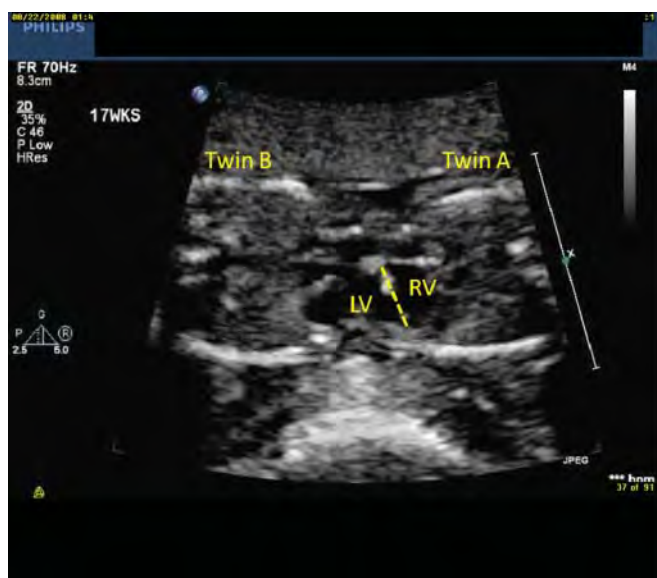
Fetal echocardiography of thoracopagus twins shown in Figure 48.3, at 17 weeks' gestation. The yellow dashed line demarcates the site of connection of the two hearts between the right ventricle (RV) of twin A and the left ventricle (LV) of twin B.
